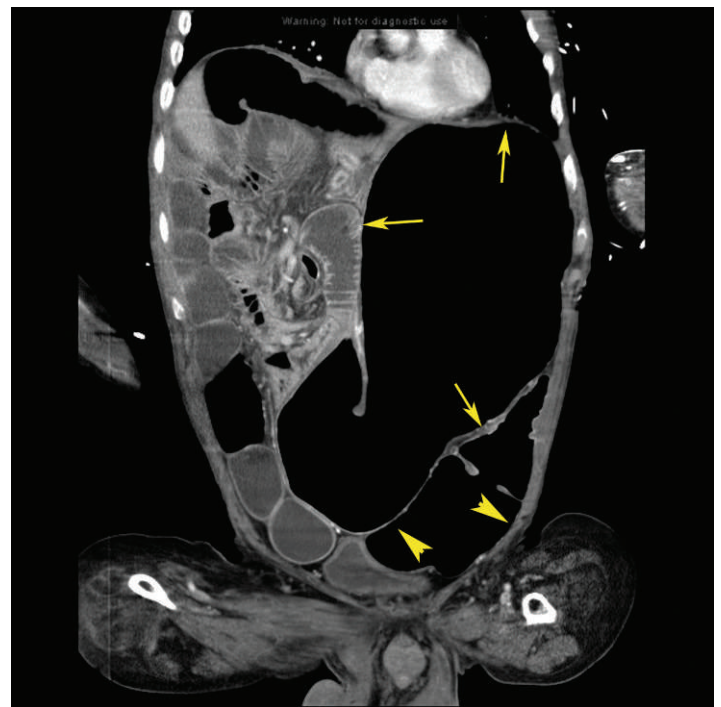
Coronal computed tomography demonstrating the massively dilated stomach (arrows) and dilated bowel loops (arrowheads).
